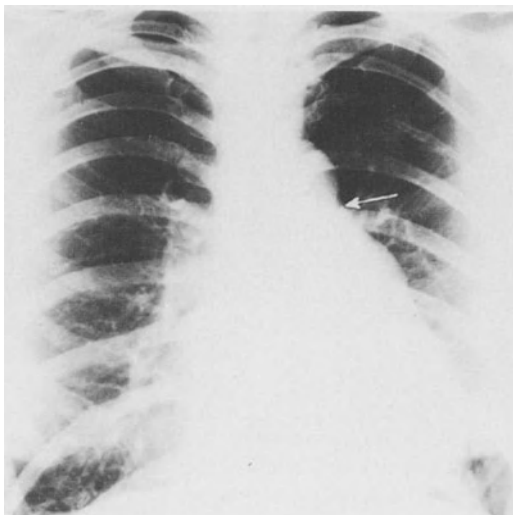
The X-ray in patent ductus arteriosus with large left-to-right shunt and pulmonary hypertension showing an enlarged aorta and pulmonary artery with filling in of the notch between the two (arrow).
